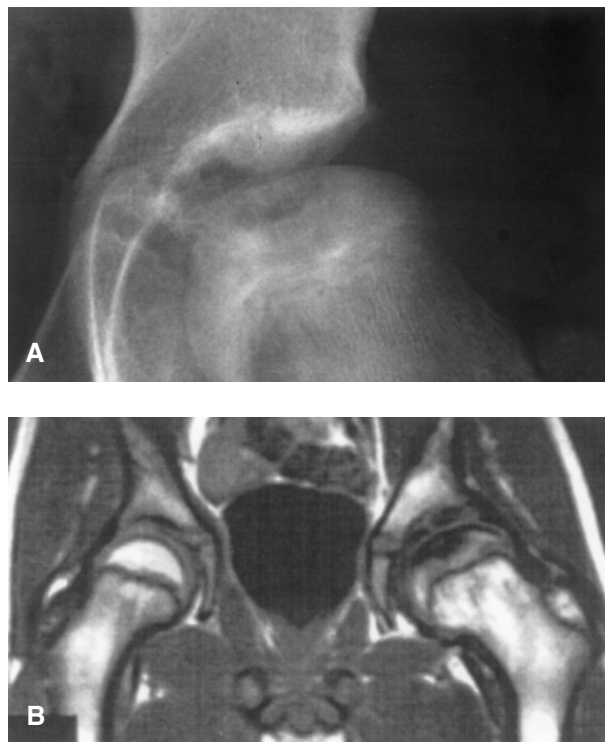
Patient 10 at age 12. OD after LCPD. A) A.p. view. A defect in the left femoral head is seen. B) MR with T1-weighted coronal section through both hip joints. The lesion in the left femoral head has low signal. The lesion appears larger than on radiography, probably due to edema around the lesion.
